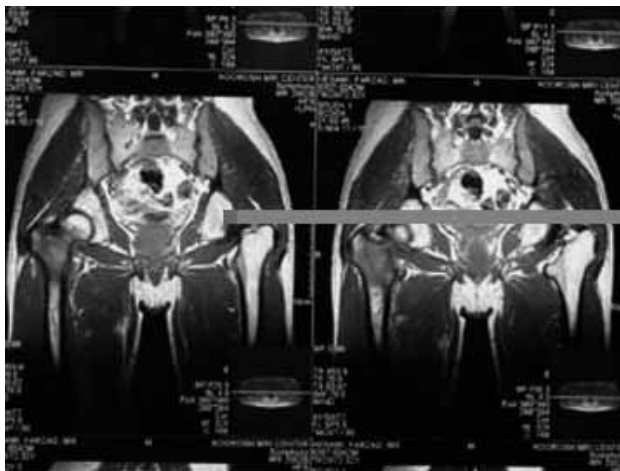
Metastasis in right femur in MRI.
